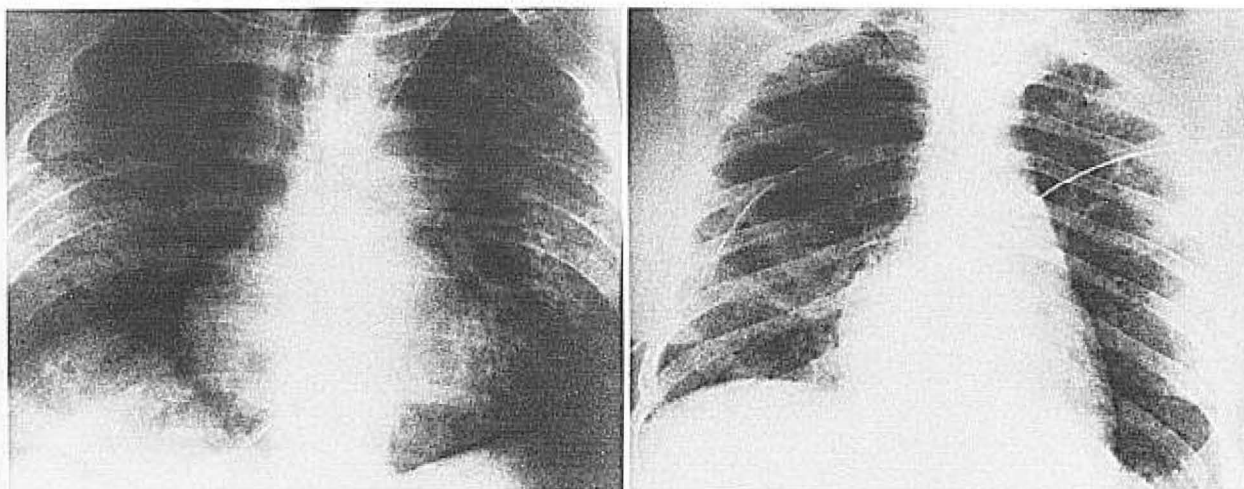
Cytomegalovirus pneumonia. The chest radiograph on the left is from the case report described in the protocol and shows diffuse alveolar infiltrates. The radiograph on the right shows diffuse reticulonodular infiltrates in a woman with systemic lupus erythematosus treated with steroids and cyclophosphamide.
